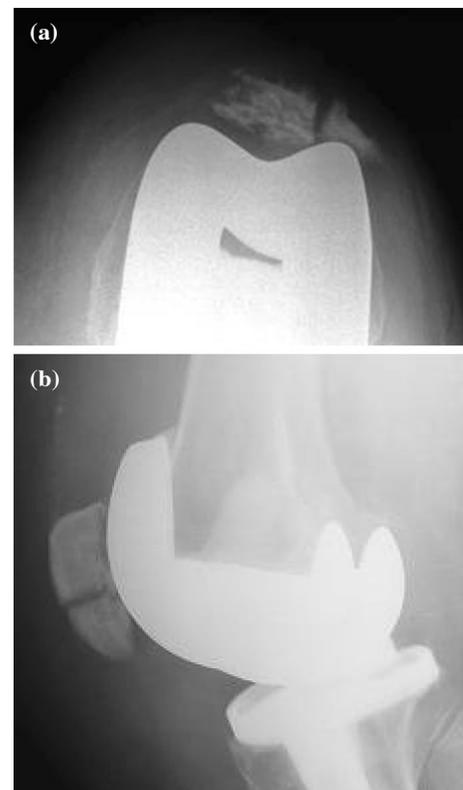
a Merchant view of vertical fracture in a non-replaced patella in a total knee arthroplasty. b Lateral view of knee radiograph of a horizontal fracture in a non-replaced patella after total knee arthroplasty
